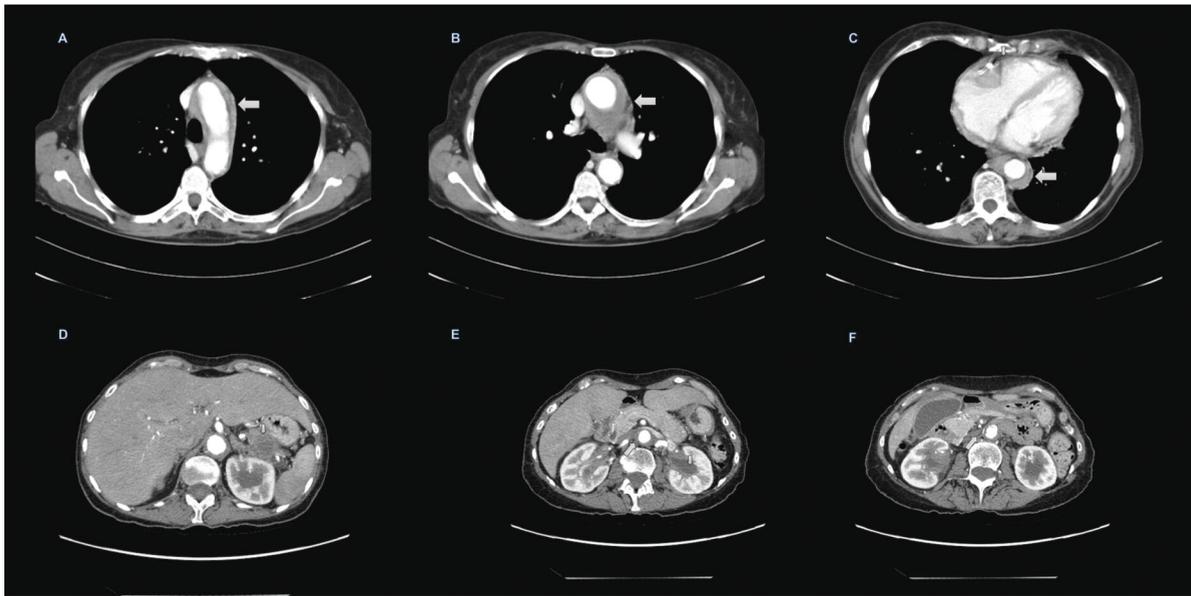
Computed tomography (CT) scan (axial views). A, B and C (thoracic CT) revealing a non aneurismal form of periaortitis involving the ascending and descending aorta (big arrows). D, E and F (abdominal CT) revealing a periaortitis of the aorta (big arrows). It also shows a hypodense and heterogeneous area in the tail of the pancreas (small arrow-image D) and calyceal dilatation (small arrow-image E).
